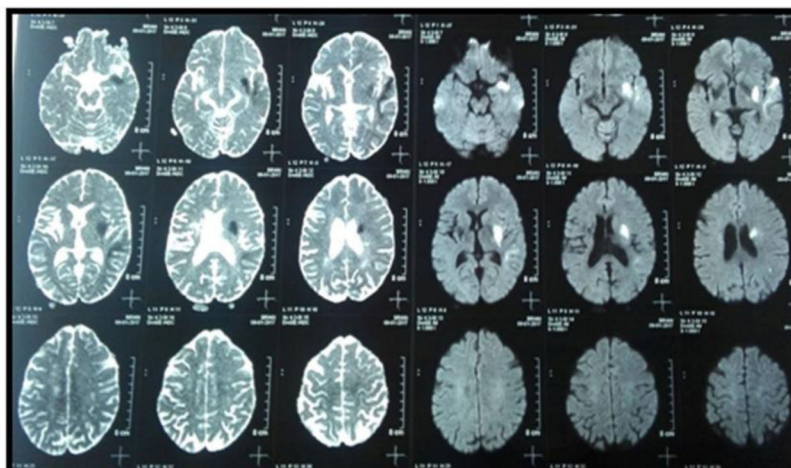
Brain MRI with DWI sequence showed an area of restricted diffusion of the left basal ganglia, internal capsule, operculum, with a corresponding hypodensity in the ADC map.
